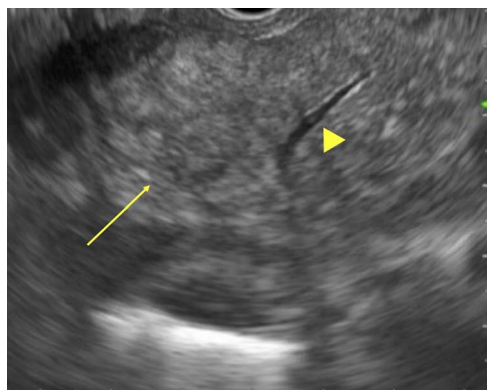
Endoscopic ultrasonography shows diffuse swelling of the pancreas and coarse parenchymal texture (arrow). There is no dilation of the main pancreatic duct. (arrowhead).
